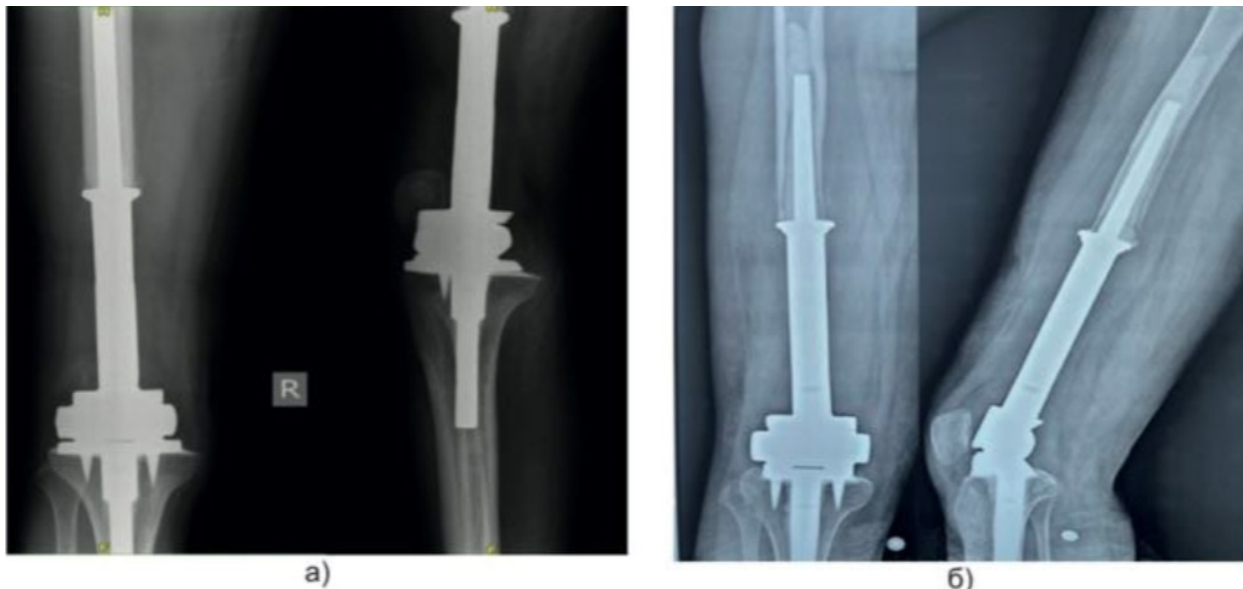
Radiographs. Condition after resection of the distal femur and proximal articular surface of the tibia with knee arthroplasty: a) early postoperative period; b) 5 years later
